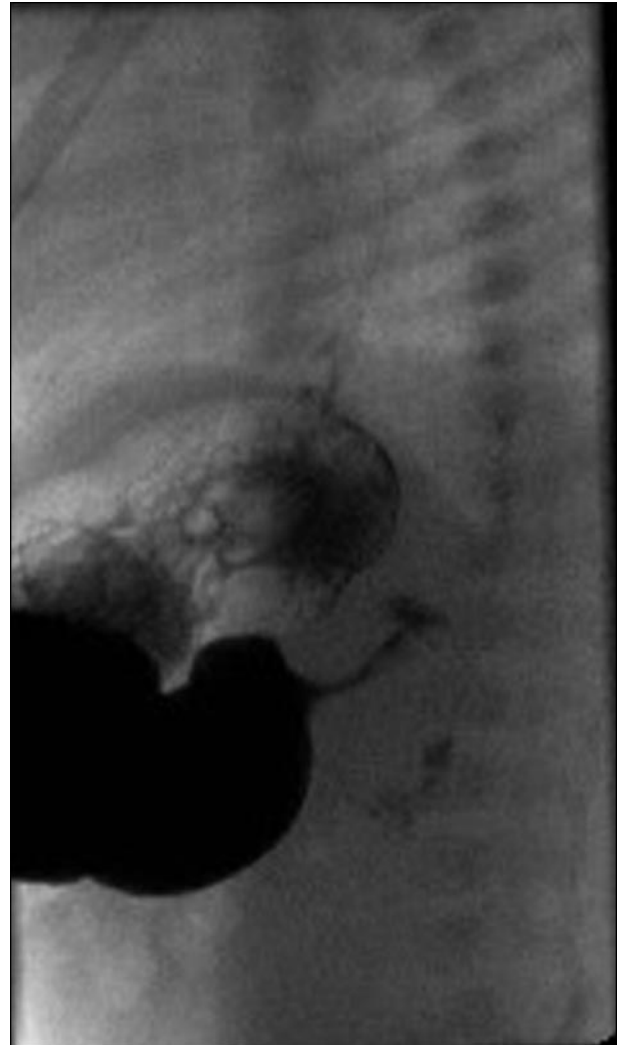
Upper gastrointestinal radiographic series in a 4-month-old boy who has vomiting and failure to thrive shows delay in gastric emptying and an elongated pyloric channel consistent with pyloric stenosis.
